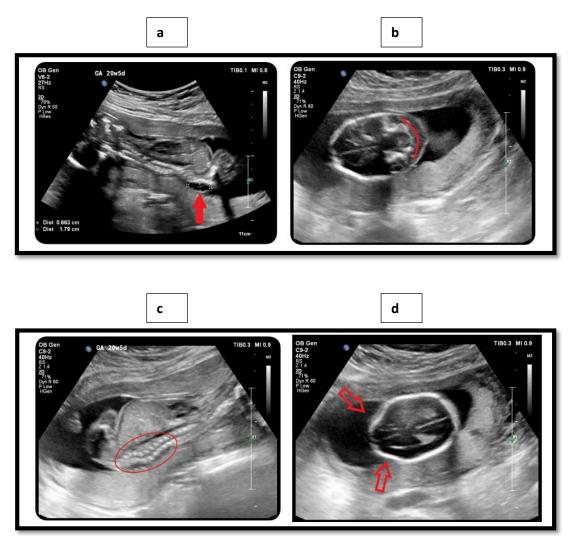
A 2 – D ultrasonography of the fetus at 20 weeks and 5 days of gestation showing (a) meningomyelocele in the lumbosacral region (b) posterior cranial fossa defect – "Banana sign" (c) kyphoscoliosisin lumbosacral region of spine (d) concavity of the frontal bones "lemon sign" (Simona et al.2021)
